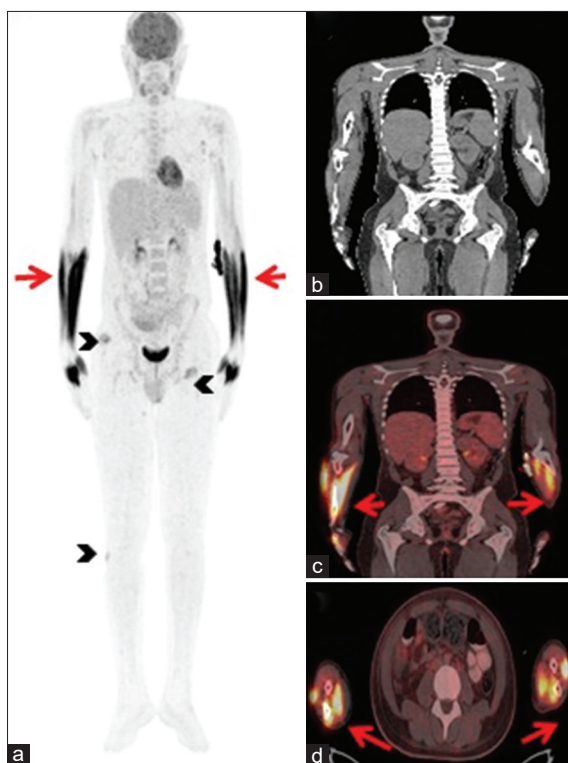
A 21-year-old male complained of fever and yellowish discoloration of sclera and skin for the last 10 days. He was diagnosed with acute viral hepatitis A with acute liver failure. He developed multiple foci of pyoderma in the right gluteal, left inguinal, and right knee with resultant itching. He underwent ¹⁸F-fludeoxyglucose (FDG) positron emission tomography/computed tomography (PET/CT) to look for the extent and localization of infective foci. Maximum intensity projection image (a) showed increased tracer uptake in the infective foci in the right gluteal, left inguinal region, and right upper leg region (black arrowheads) with additional intense tracer uptake in the bilateral forearms (red arrows). Coronal CT and fused PET/CT images (b and c) and axial fused PET/CT (d) of ¹⁸F-FDG PET/CT shows increased FDG uptake in the bilateral forearm muscles consistent with the history of itching mimicking the “hot forearm sign”
